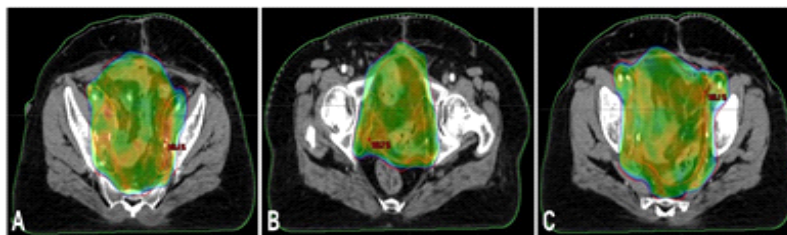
PET-CT Radiation Therapy Planning for Bladder Carcinoma
